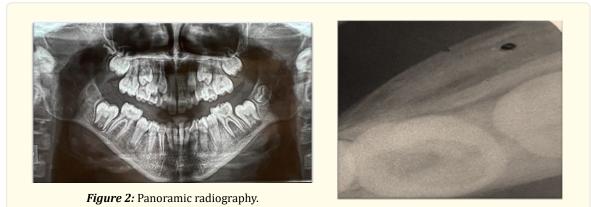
Occlusal radiography showing thickening of the vestibular periosteum.
